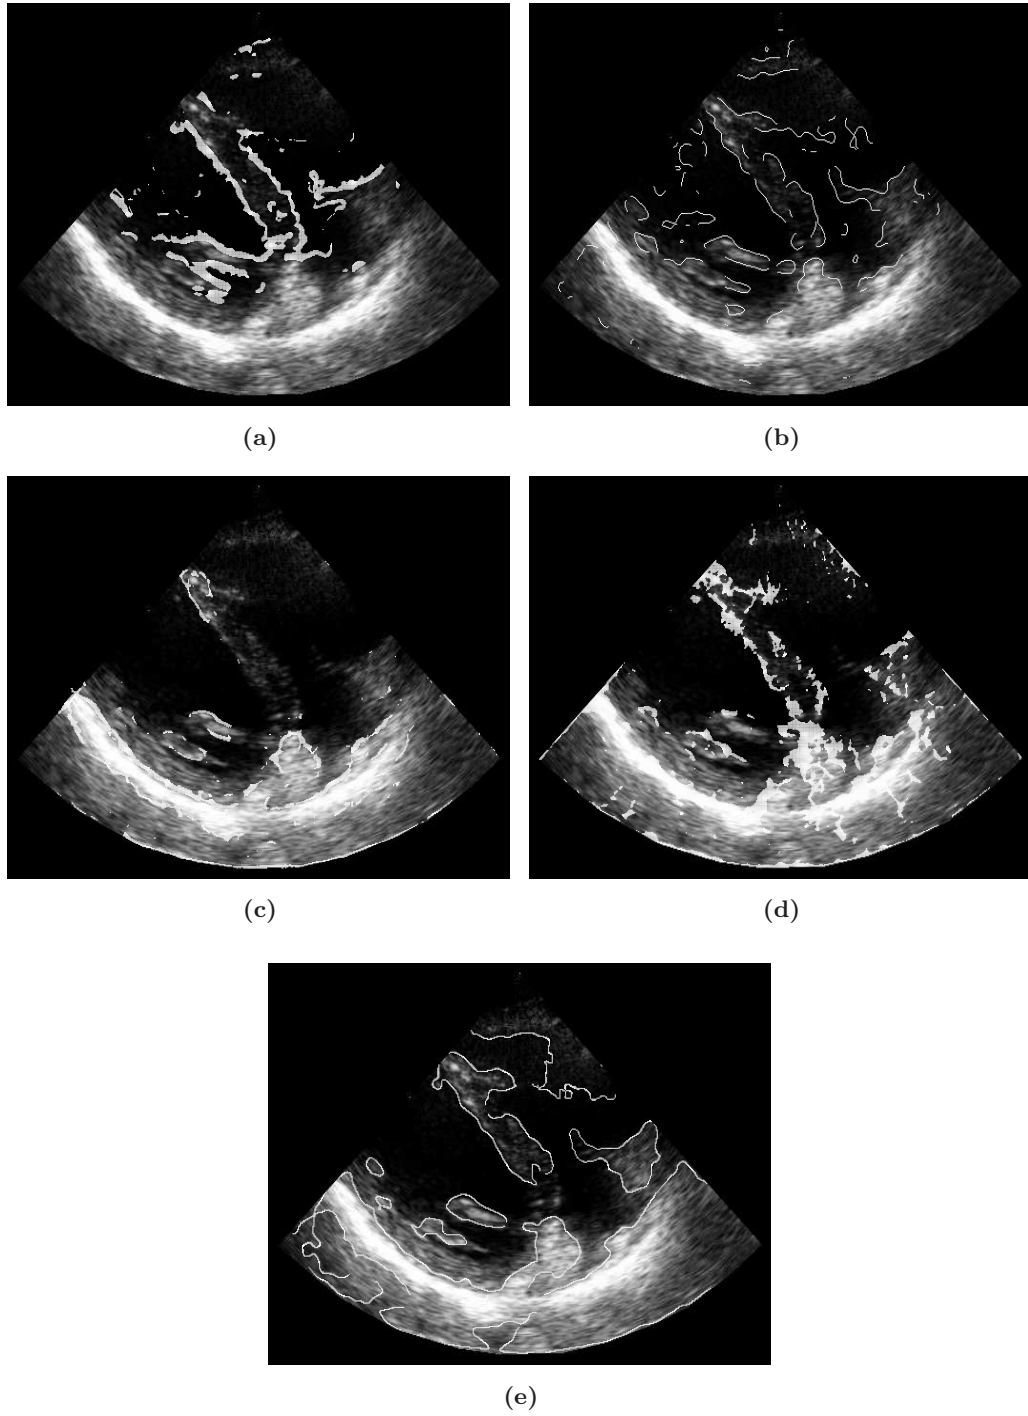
Edge detector output for the clinical ultrasound images of Fig. 6.7(f). (a) CV, (b) RoA, (c) FA, (d) PC, (e) ZC.
